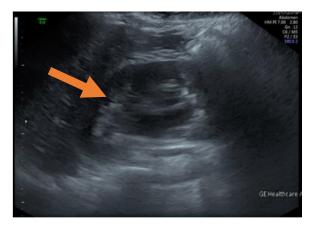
Ultrasound of the pelvis showing retroperitoneal hematoma as pointed by the arrow.
